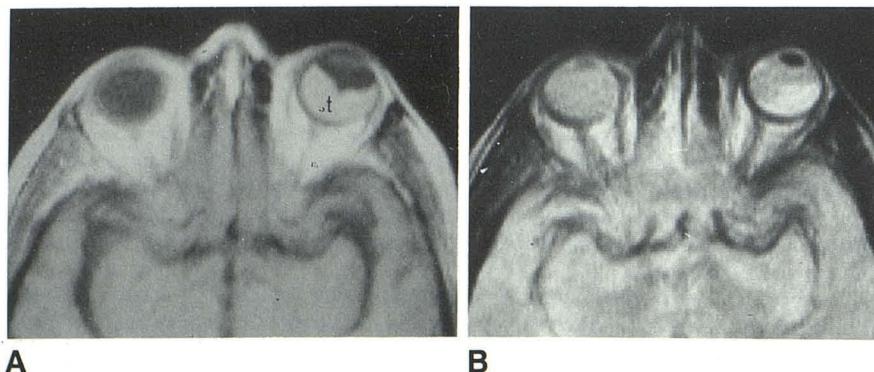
Choroidal melanoma. SE 500/30 (A) and SE 2000/60 (B). Large tumor mass (t) occupies posterior part of left globe, which is optimally demonstrated on T1-weighted pulse sequence (A), where tumor has short T1 relative to adjacent vitreous, providing sharp contrast. However, on T2-weighted pulse sequence (B), contrast between tumor and vitreous is less, and tumor is not readily visible.
